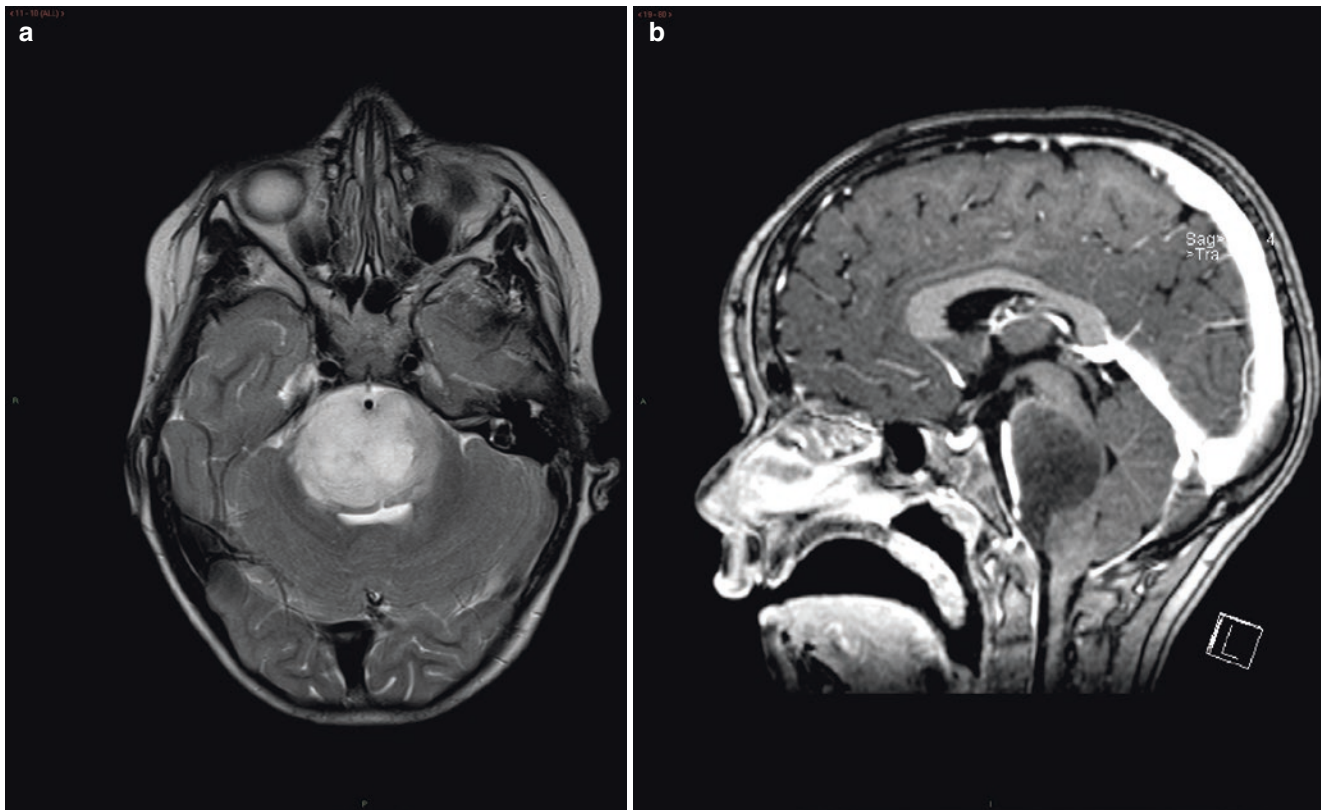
Diffuse pontine glioma. (a) Axial T2-weighted MR image demonstrates a high-signal mass within the pons. (b) Sagittal post-contrast T1-weighted MR image shows that the tumour does not enhance with contrast
